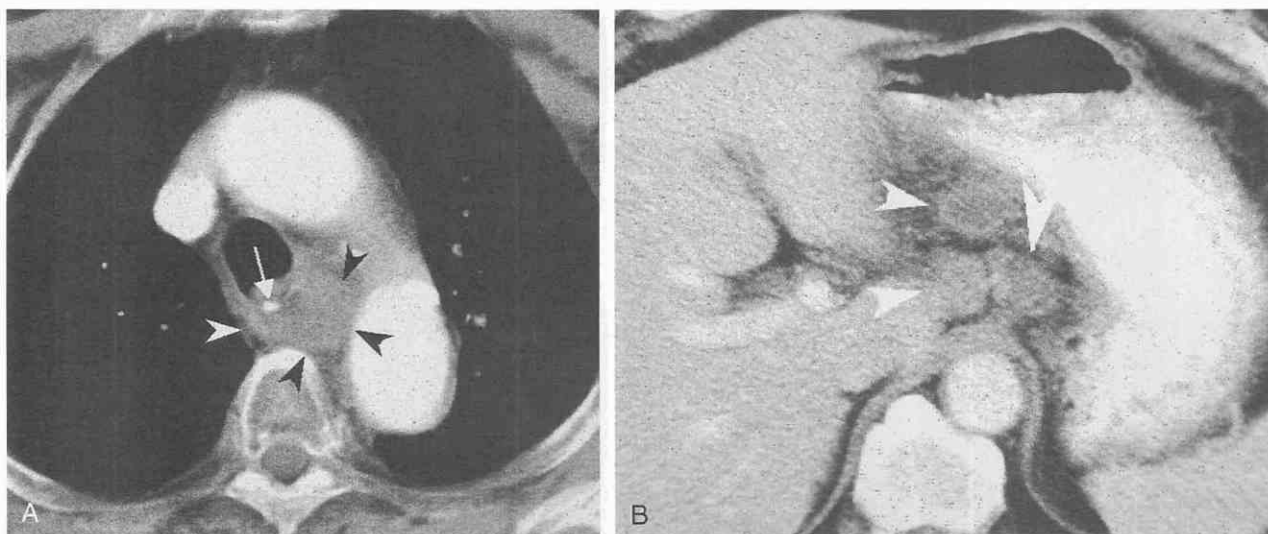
Small cell carcinoma of the esophagus. A, CT scan at the level of aortic arch demonstrates eccentric wall thickening with soft tissue attenuation in the proximal esophagus. The esophageal lumen (arrow) is filled with contrast medium. B, CT scan of the upper abdomen demonstrates multiple enlarged lymph nodes (arrowheads) in the perigastric area.
